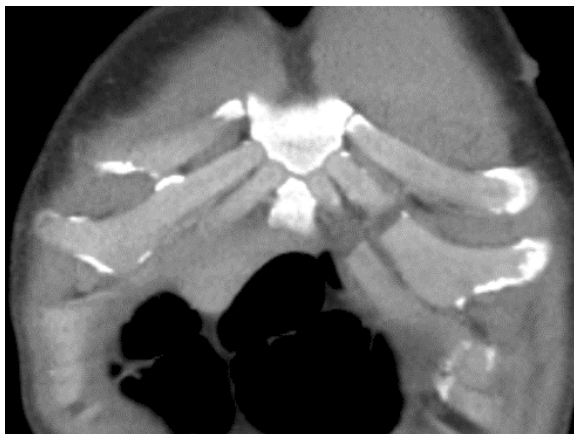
Exemplary case of typical midchondral fractures in ribs 6 and 7 (left side) on a coronal CT image. Fractures of the subcostal angle are more easily detected in coronal plane.
